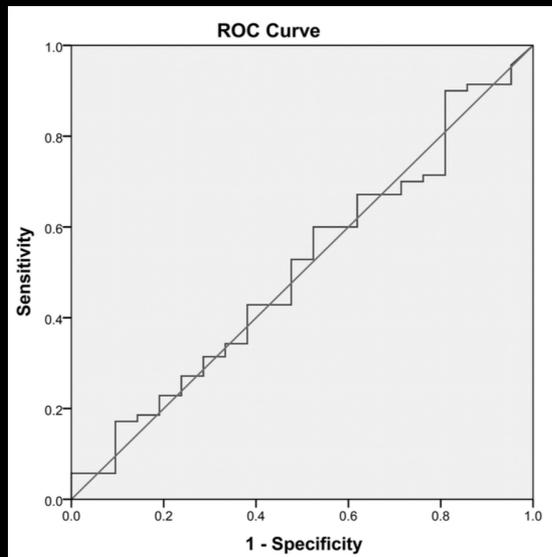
Receiver operating characteristic curve demonstrating no association between the time from LSW to MR imaging (0–3 hours versus 3–6 hours) and DWI infarct volume.
